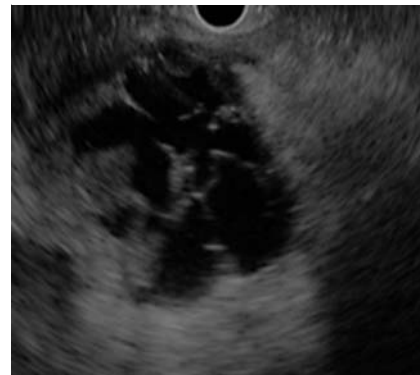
Endoscopic ultrasound (EUS) revealed a 5-cm complex septated cystic lesion located near the head of the pancreas and abutting the inferior vena cava.
